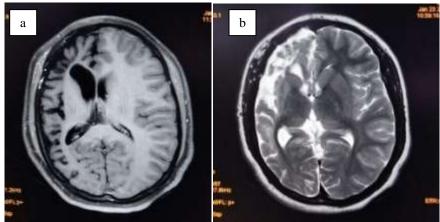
On axial sections of MRI Brain, T2/FLAIR shows atrophy of the right cerebral hemisphere with right fronto-parietal cytic encephalomalacia with ex-vacuo dilated right lateral ventricle.
